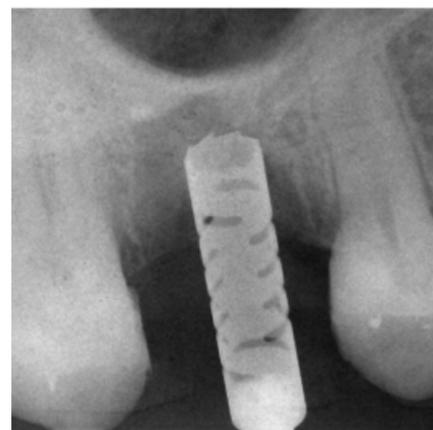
An intraoperative X-ray picture with a trephine *in situ*. The semicircular holes of the trephine enable its use as a gauge.
